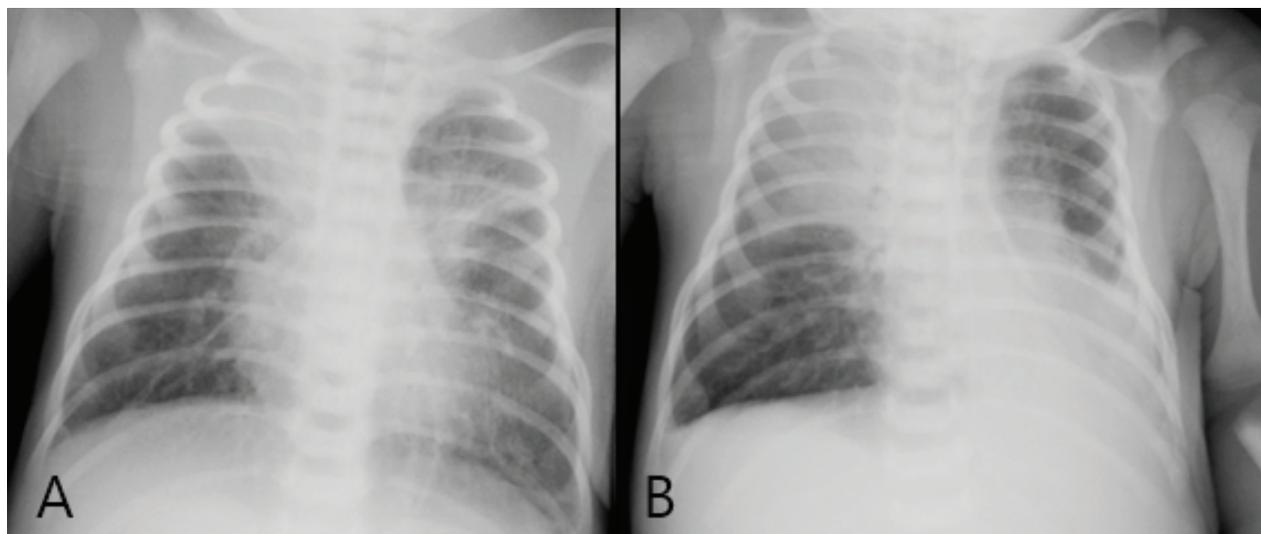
Chest X-ray of the newborn. A) Twenty-four hours after admission: opacities of the upper right and lower-left lung B) Seven days after admission: massive opacification of the right lung and of lower-left lung. i.v.
